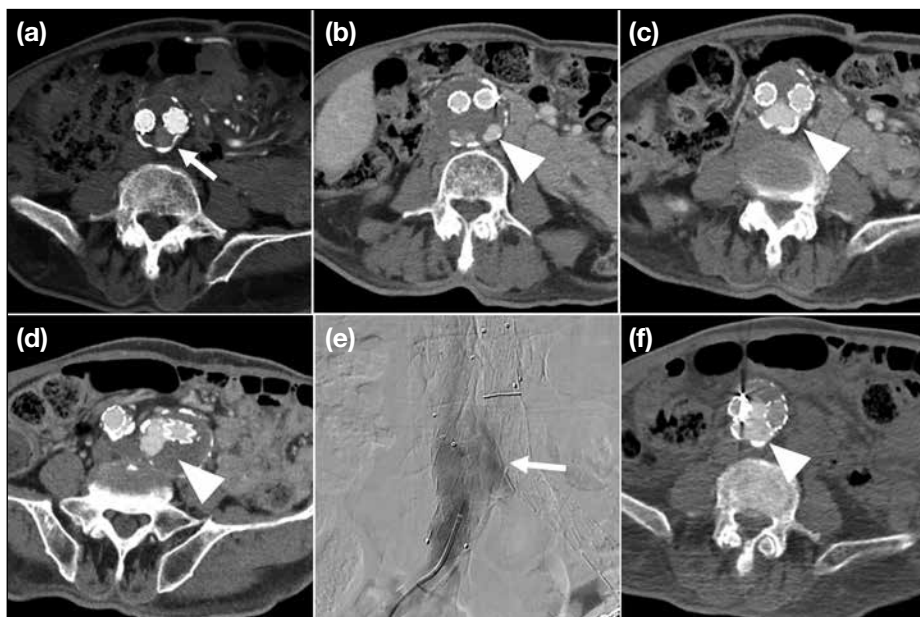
A 76-year-old male patient. (a) Initial computed tomography aortogram shows endoleak within posterior aspect of the distal aortic aneurysmal sac (arrow). It was originally thought to be a type II endoleak from the median sacral artery. (b-d) Upon follow-up computed tomography aortography increasing diameters of abdominal aortic aneurysm and left common iliac artery aneurysm were noted, with increased endoleak within the aortic aneurysmal sacs (arrowheads). (e) An aortogram with intra-arterial injection in the right iliac limb. There was abnormal contrast leakage near the distal abdominal aortic aneurysm sac and the right common iliac artery aneurysmal sac (arrow). (f) Angiography-computed tomography with intra-arterial contrast injection via the right iliac limb shows an endoleak originating from the right iliac endograft, consistent with a type IB endoleak (arrowhead).
